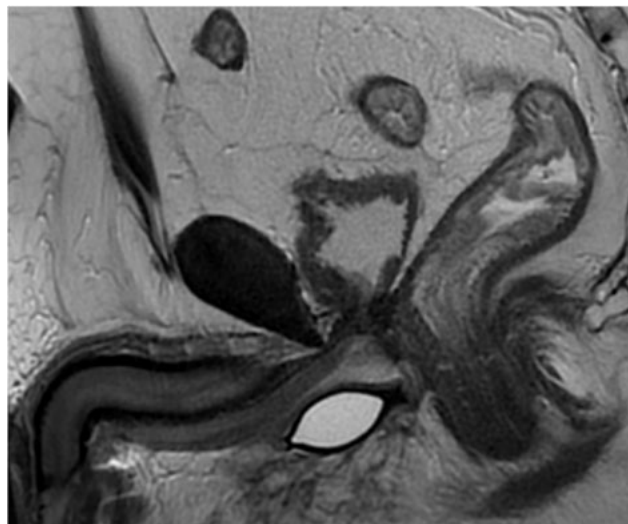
Magnetic resonance imaging showing the Atoms sling. Courtesy of Dr. Argimiro Collado Serra
